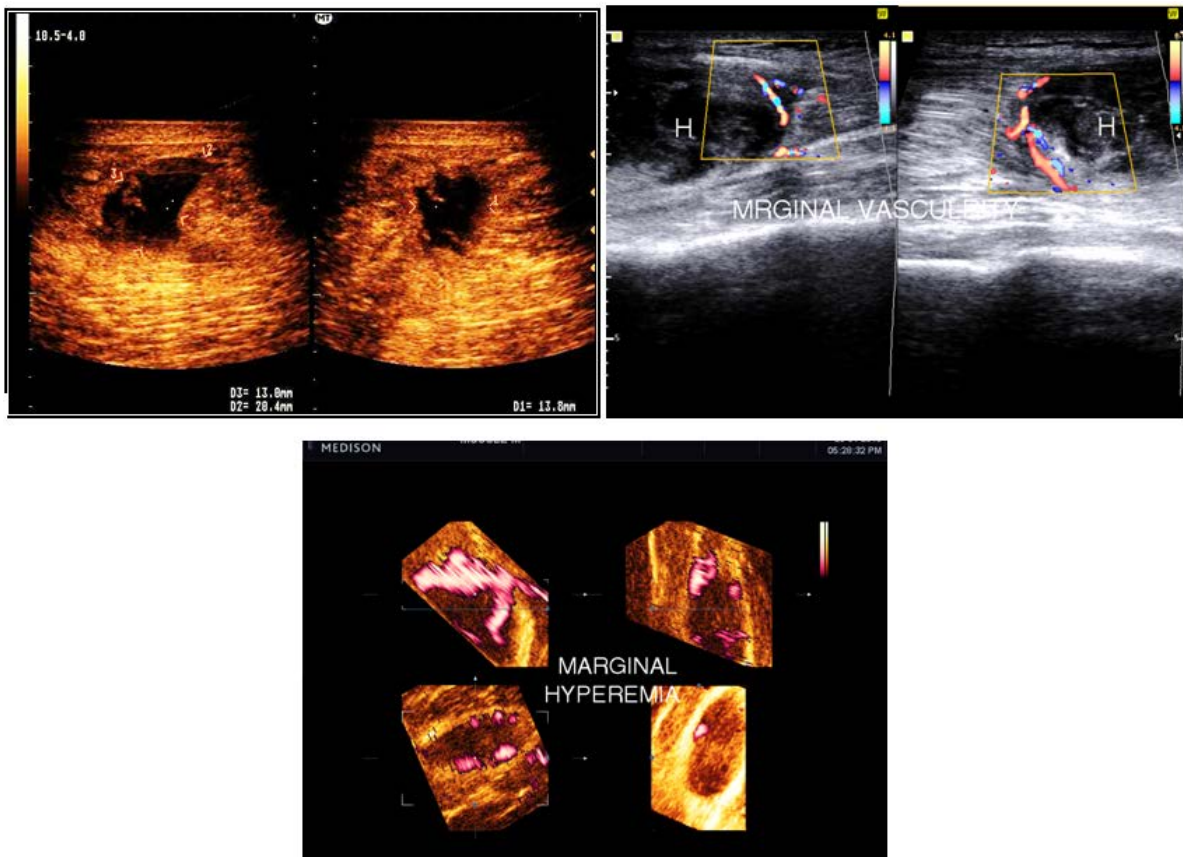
a. 2D sonography of partial muscle tear with hematoma formation, b. Color Doppler study of Partial muscle tear with marginal hypervascularity, c. 3D Power Doppler of partial muscle tear with marginal hyperemia
